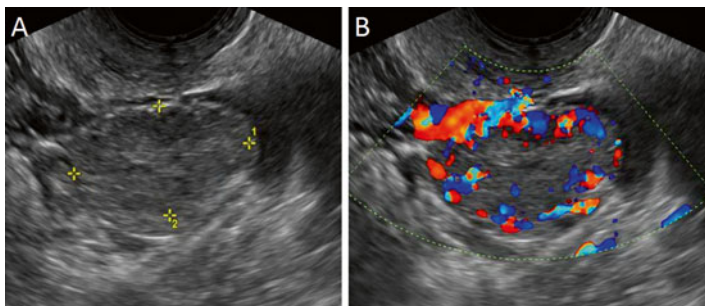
Corpus luteum. (a) Transvaginal ultrasound reveals a 3-cm corpus luteum (*calipers*) with internal echoes; (b) peripheral flow is seen by color Doppler
